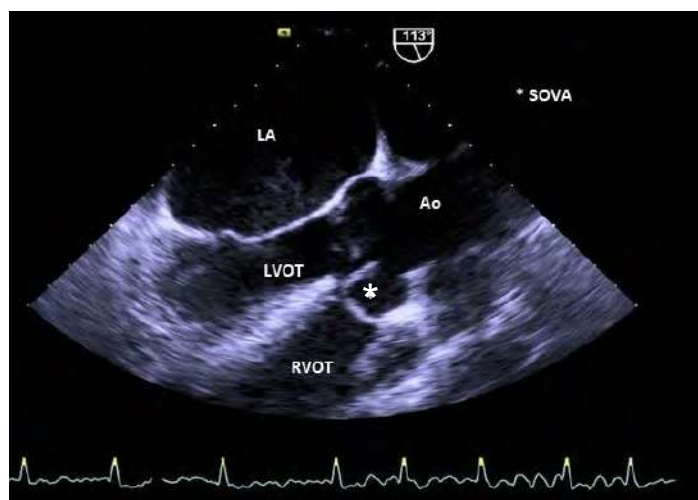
Transesophageal echocardiogram demonstrating an eccentrically aneurysmal right sinus of Valsalva (star). LA, left atrium; LVOT, left ventricle outflow tract; Ao, aorta; RVOT, right ventricle outflow tract; SOVA, sinus of Valsalva aneurysm.
